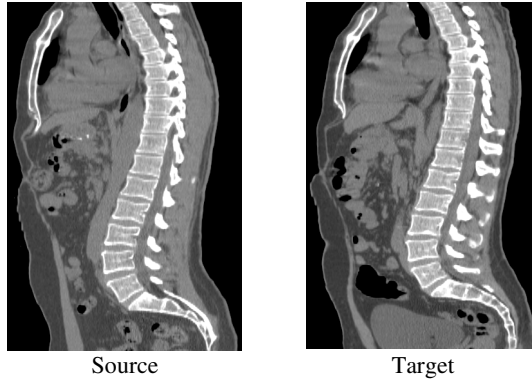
Sagittal sections of whole-body CT image dataset analysed in this study
